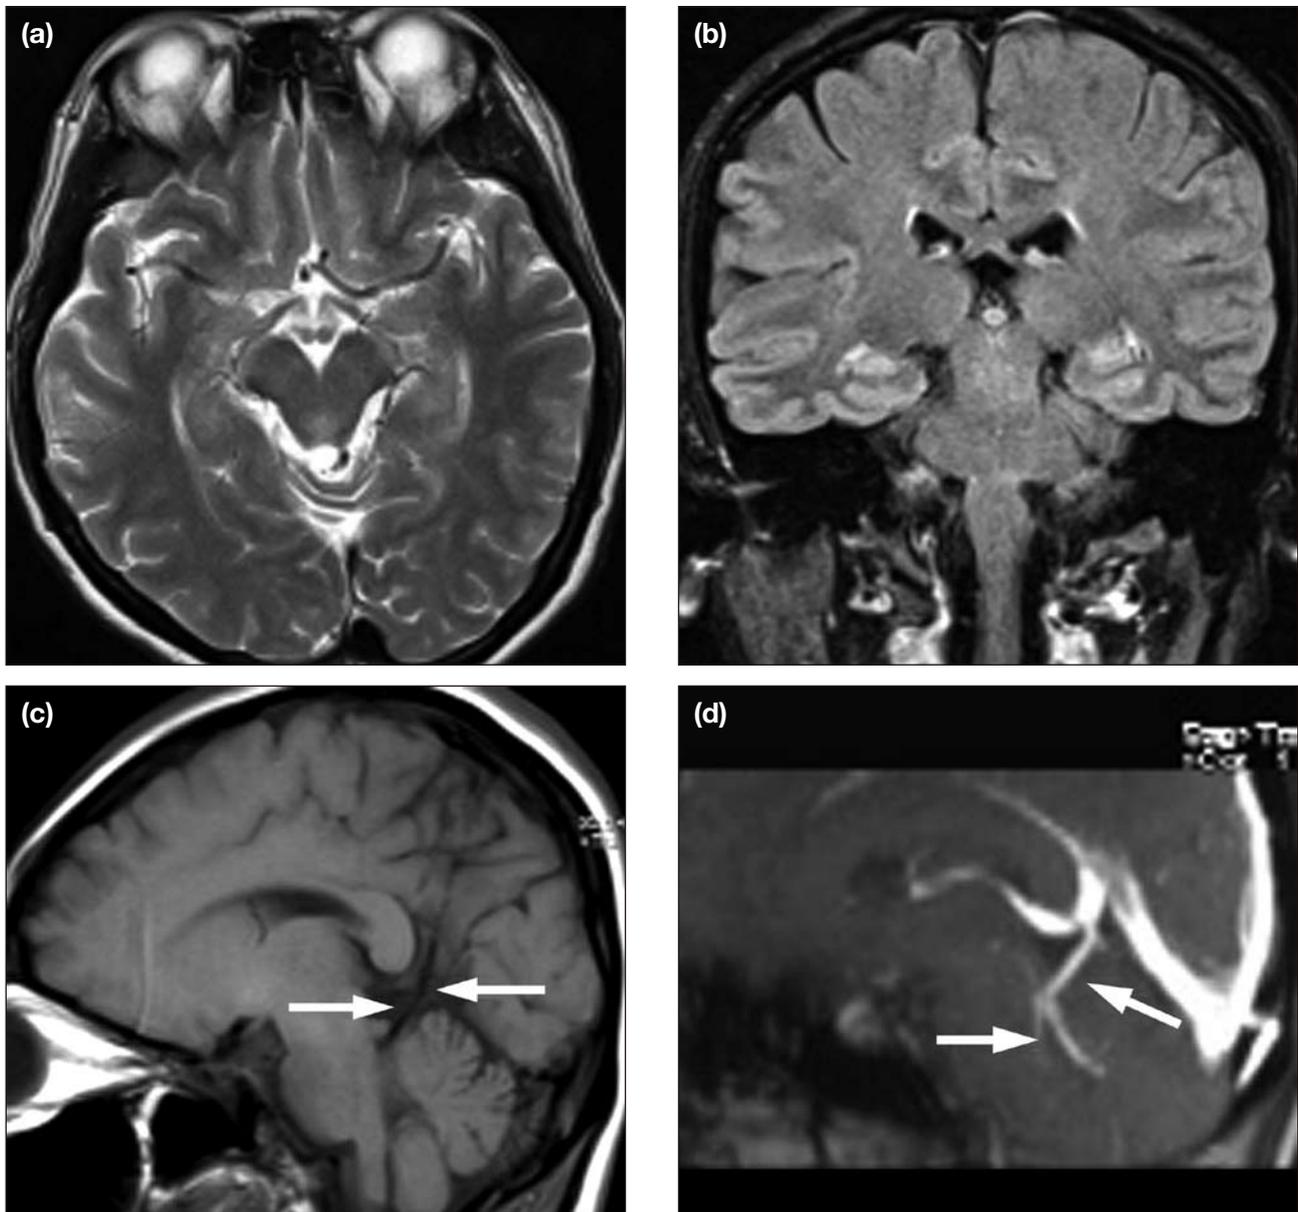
Magnetic resonance images of the brain. (a) Axial T2-weighted image showing subsidence of the T2 hyperintensity in the brainstem; (b) coronal fluid attenuation inversion recovery image of the brain showing the absent T2-weighted hyperintense signal along the brainstem; (c) sagittal T1-weighted image showing recanalisation of the previously thrombosed draining vein flow void (arrows); and (d) sagittal venogram demonstrating the venous angioma draining into the great vein of Galen (arrows).
